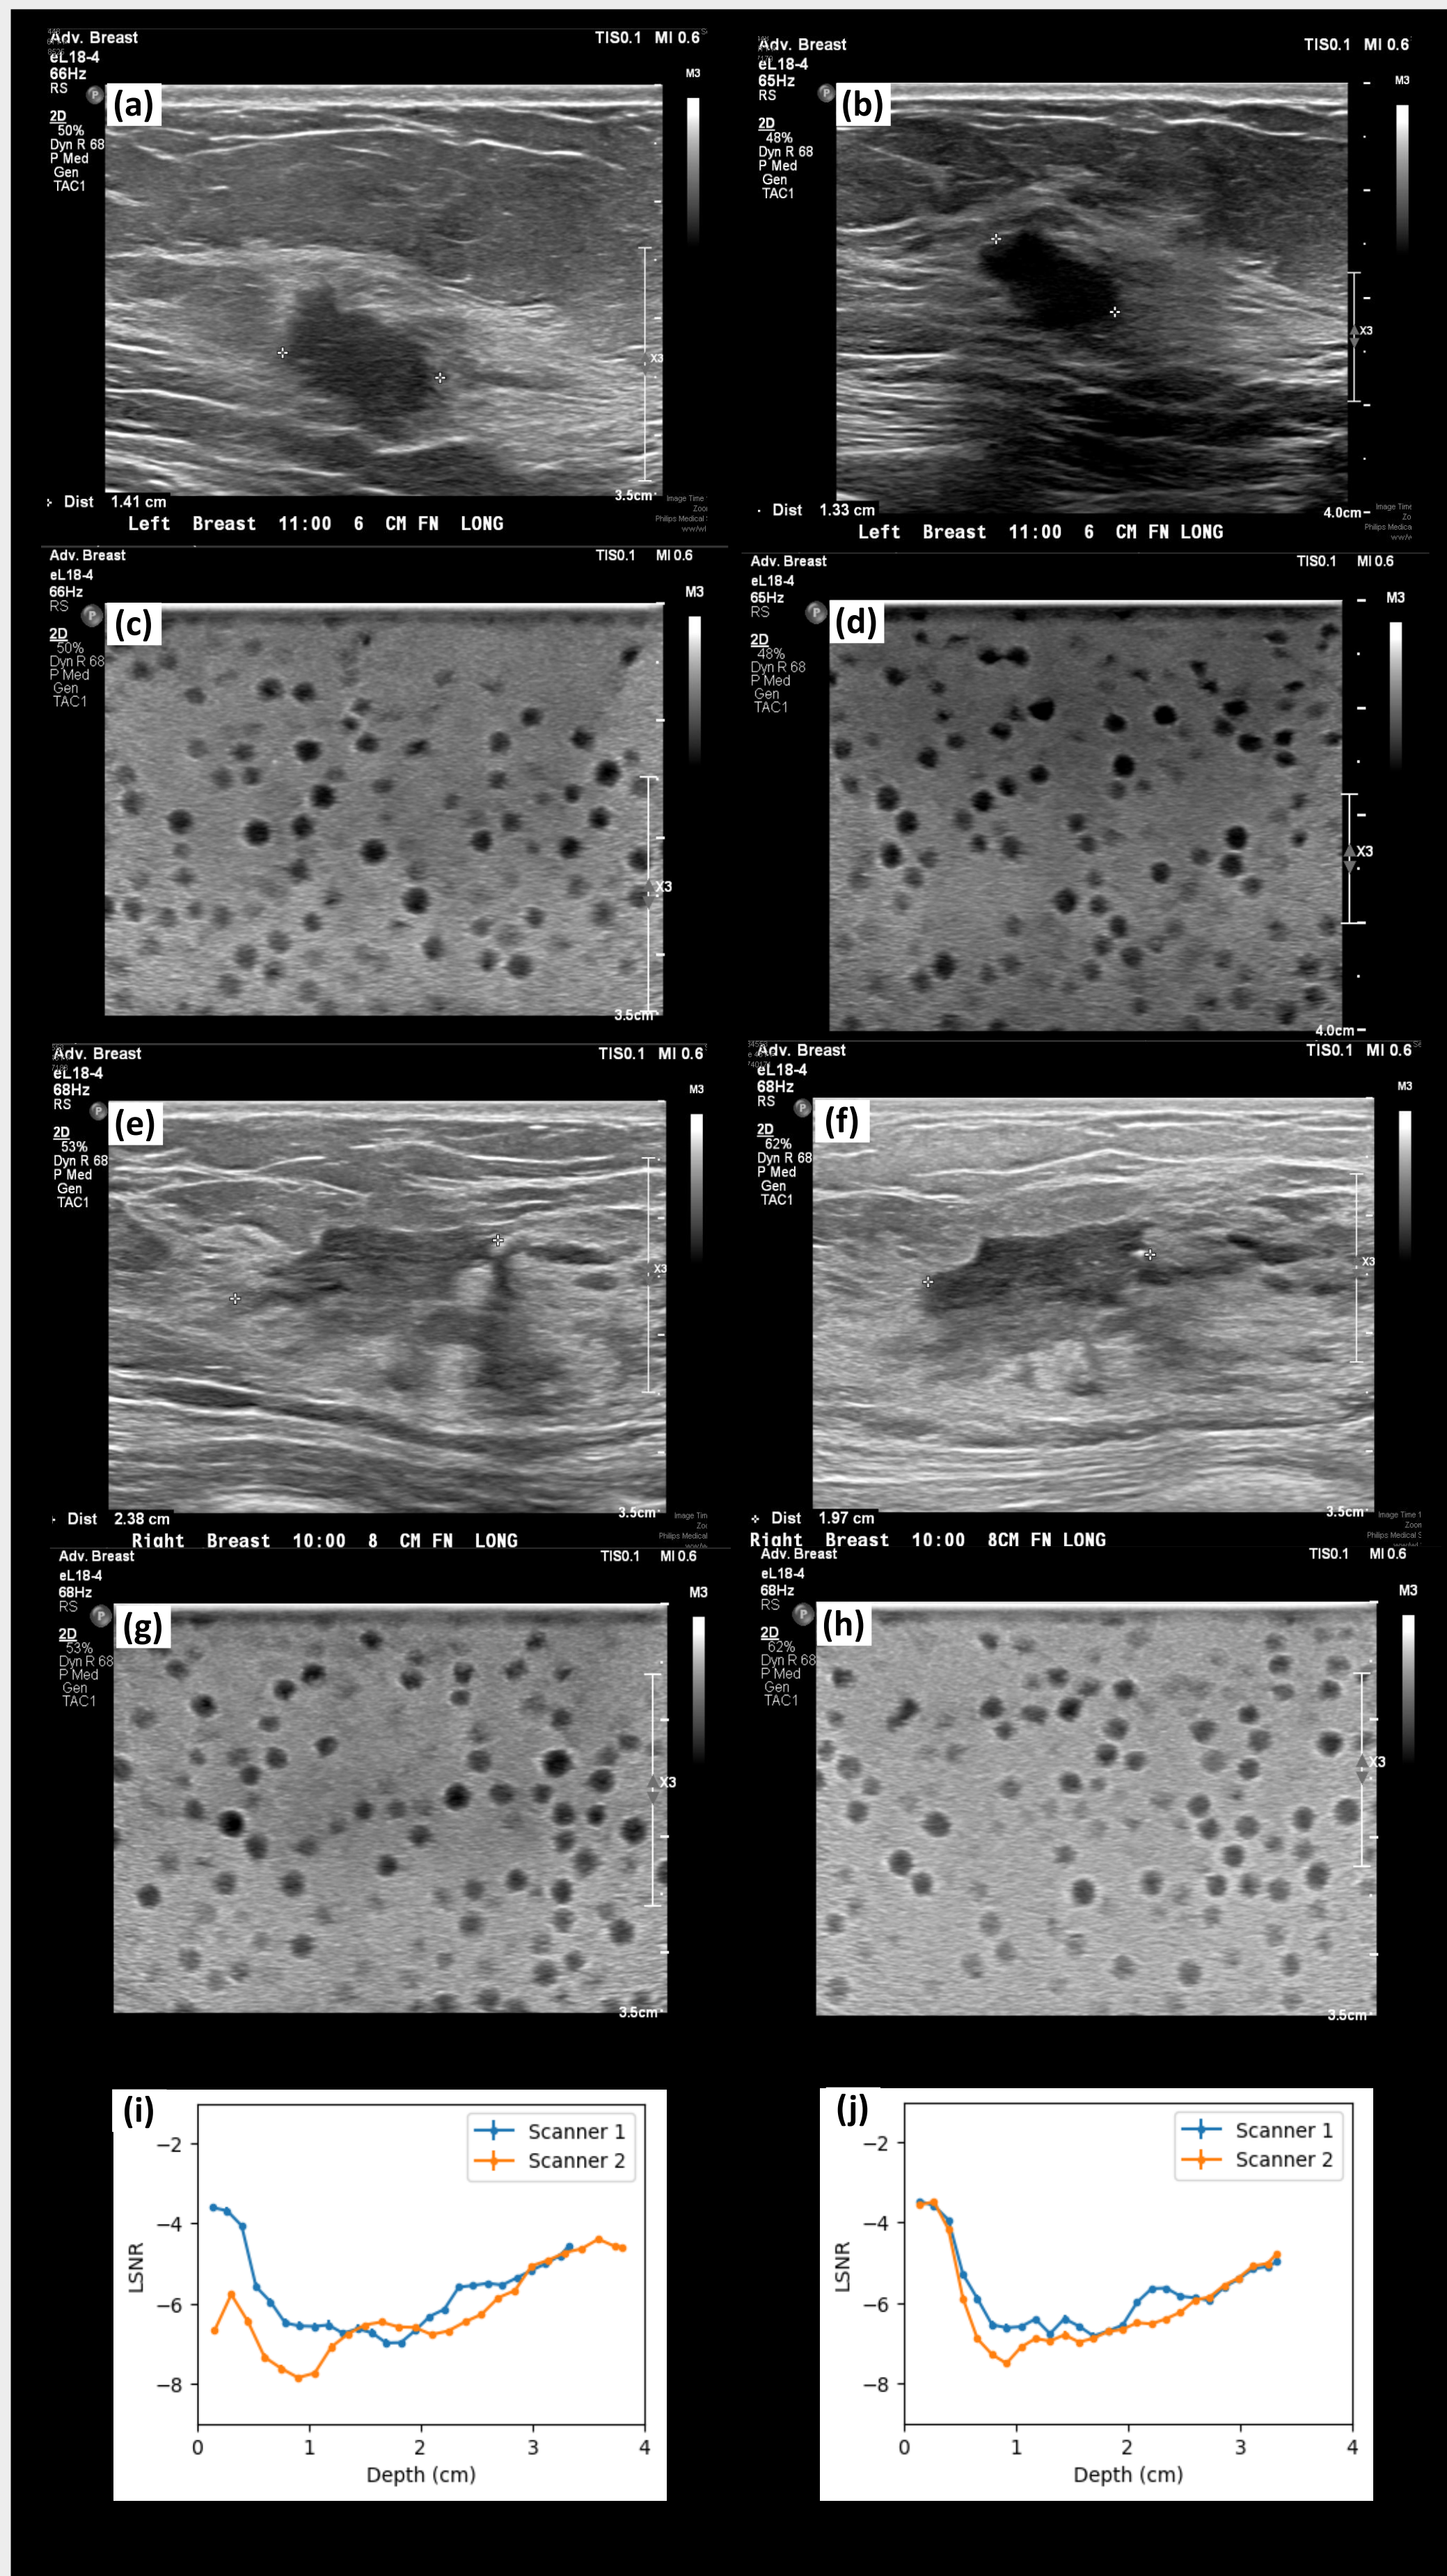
(a) - (b) Breast ultrasound images from patient 1 acquired on scanners 1 and 2. (c) - (d) The corresponding RHSP images using the same scan configurations as patient 1 on both scanners. (e) - (f) Breast ultrasound images from patient 2. (g) - (h) The corresponding RHSP images using the same scan configurations as patient 2. (i) - (j) The LSNR-versus-depth curves for the configurations of patients 1 and 2.
